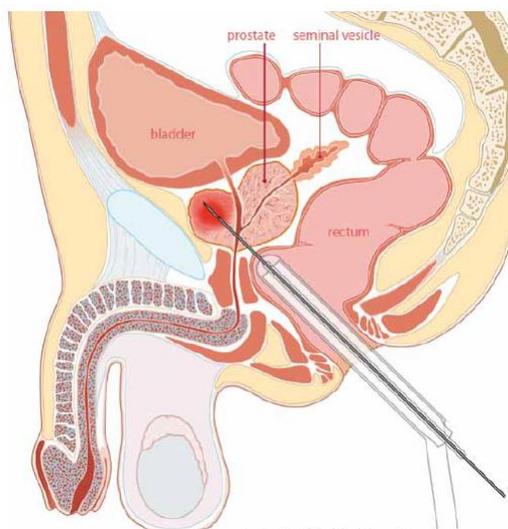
During the MRI-guided biopsy the worst part of the tumor can be specifically targeted. ⁸⁶
